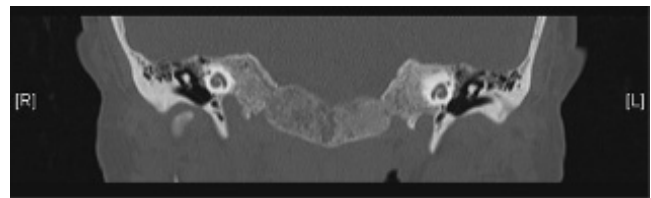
CT Paget's coronal.
